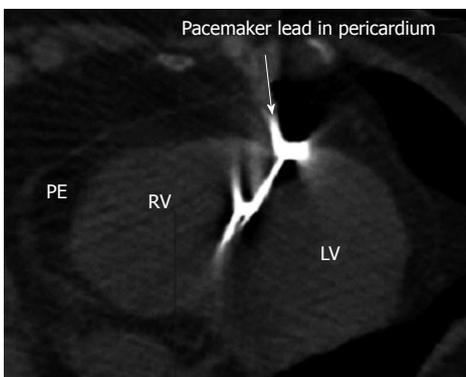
This is an axial view of a non contrast chest computed tomography confirming diagnosis of right ventricular lead perforation. The arrow points to the perforated lead. There is a pericardial effusion (PE). The right ventricle (RV) and left ventricle (LV) are also demonstrated.
